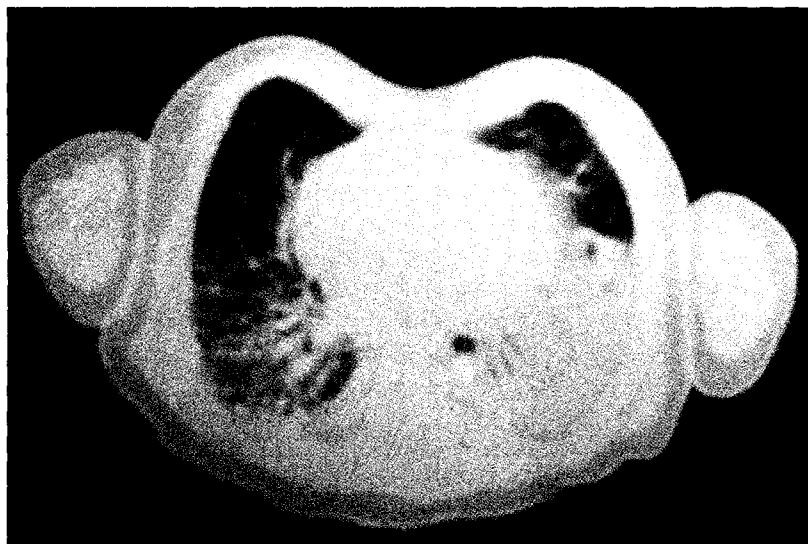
Case 2, 55 days. Helical chest CT (slice thickness 3.0 mm, pitch 1.5, reconstruction interval 3.0 mm) shows diffuse interstitial changes with thickening of the interlobular septa in the right chest (left side of image) associated with contralateral pleural fluid collection and atelectasis.
